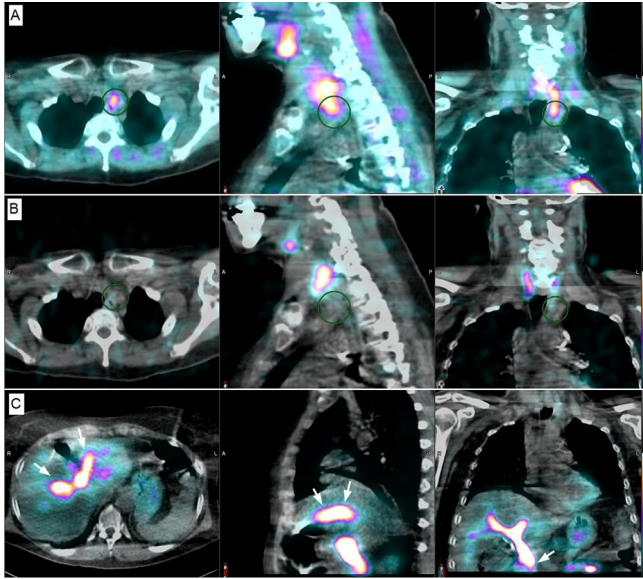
Axial, sagittal and coronal SPECT/CT images of the parathyroid scintigraphy showed a parathyroid adenoma in the left superior mediastinum positive with ^{99m}Tc sestamibi (Row A, circles) and negative with ^{123}I sodium iodide (Row B, circles). SPECT/CT also showed prominent tracer activity in the intra and extra-hepatic biliary ducts with cut-off sign at the distal common bile duct suggestive of obstruction (Row C, arrows).
